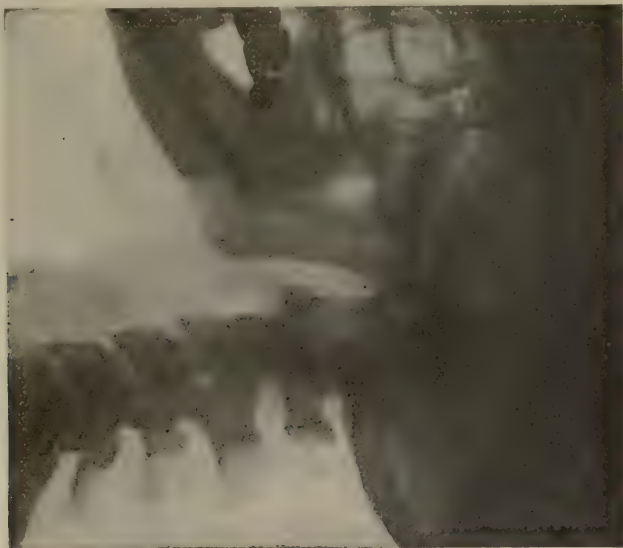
Correct position of the cervical spine for esophagoscopy and bronchoscopy. Radiograph by Dr. George C. Johnston (Chevalier Jackson).
